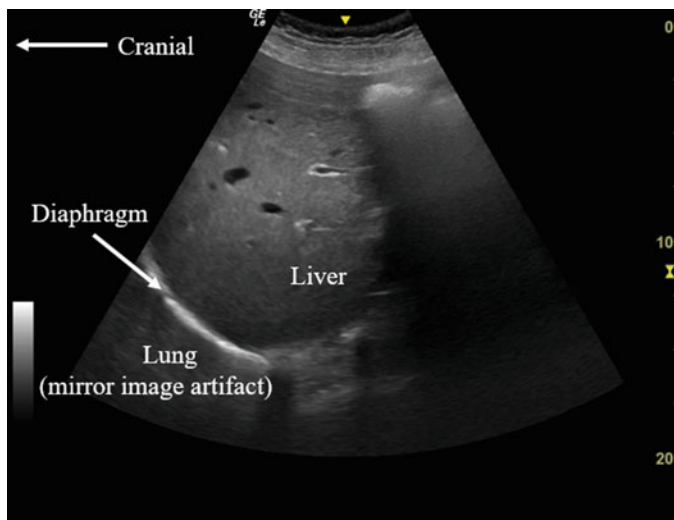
This image, obtained with a low-frequency curvilinear probe is a sagittal view of the liver, with the diaphragm appearing as a curved, echogenic structure cephalad and posterior to the liver (arrow). Anatomically, the lung lies above the diaphragm, towards the head and the left in the scanning window shown, but is not seen in this image due to the diaphragmatic reflection of ultrasound waves, resulting in a mirror image artifact
